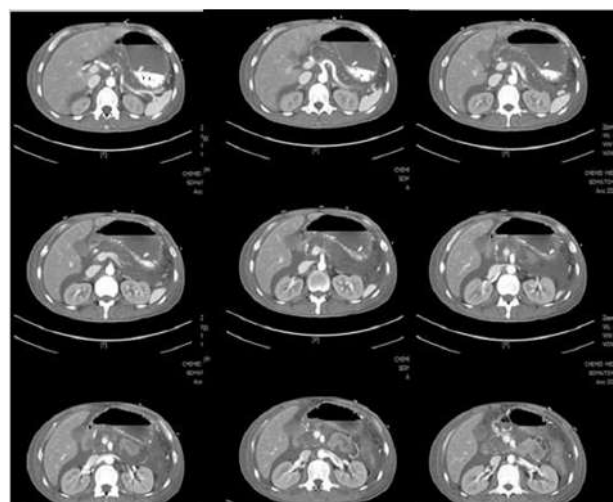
108/07/23 Abdominal computed tomography: necrotizing pancreatitis involving almost the entire pancreas is considered.
